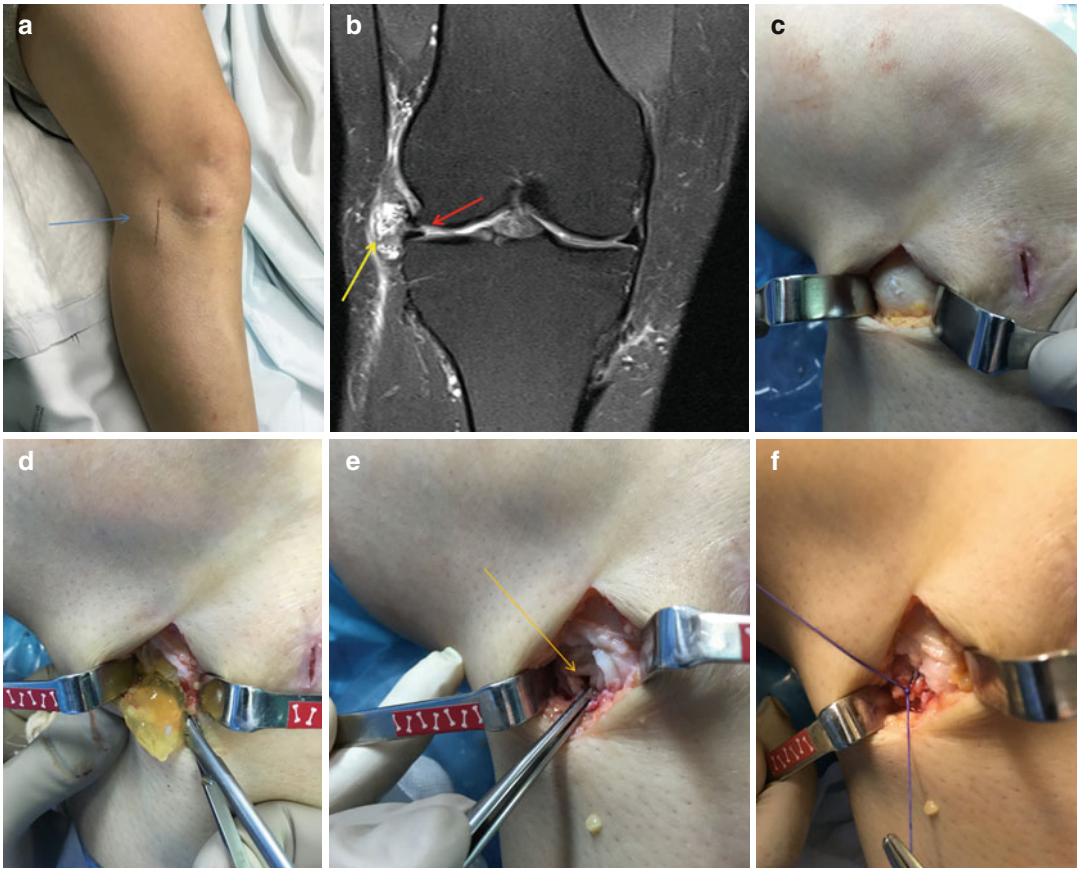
Surface anatomy view of large parameniscal cyst (a); MRI view of the cyst (yellow arrow) and horizontal cleavage tear (red arrow); open view of the cyst (c) and its content (d); horizontal cleavage of the lateral meniscus (orange arrow) (e); suture of the meniscus and capsule (f)
